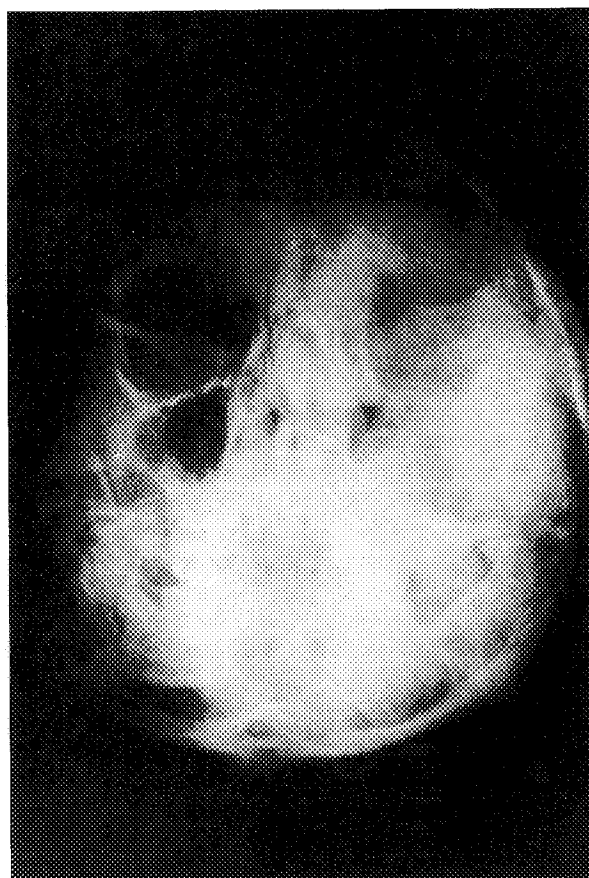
Water's view radiograph of Patient 1. The affected bone is detected as frosted glass-like in appearance with an unclear border.
